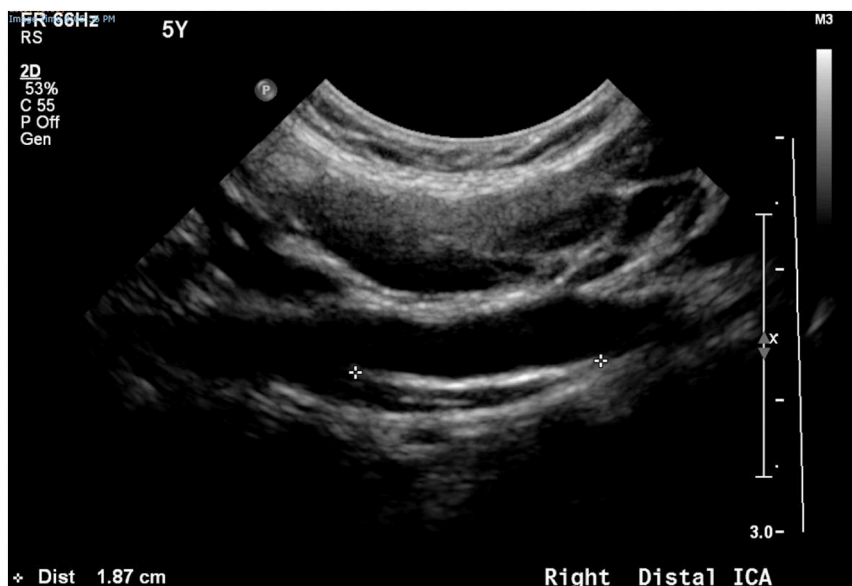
B-mode ultrasound on presentation demonstrating ICA dissection and extent of intimal flap (green cross). (For interpretation of the references to colour in this figure legend, the reader is referred to the web version of this article.)
